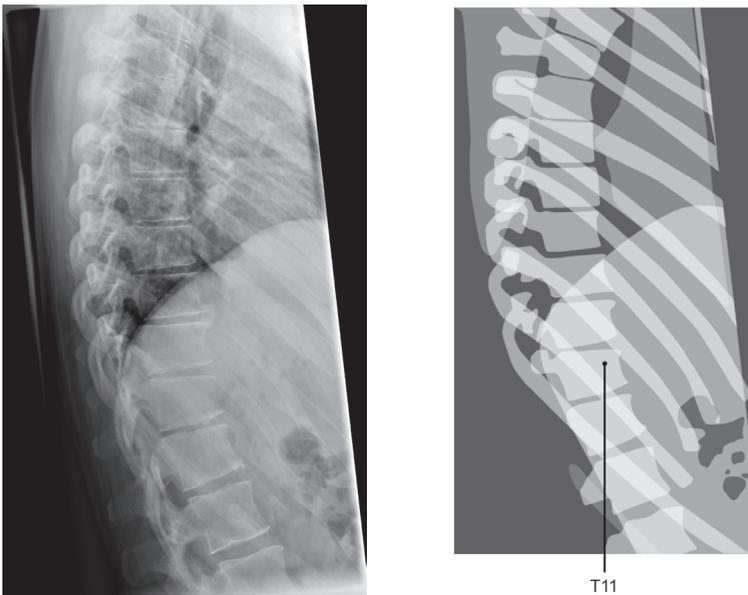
Lateral radiographs of patient B, a 42-year old man, of the mid-thoracic up to the high lumbar spine. There is presence of a wedge deformity with 28% height loss of T11 and to a lesser extent of T10 and T12, with concomitant spondylarthrotic changes of the thoracic spine.
